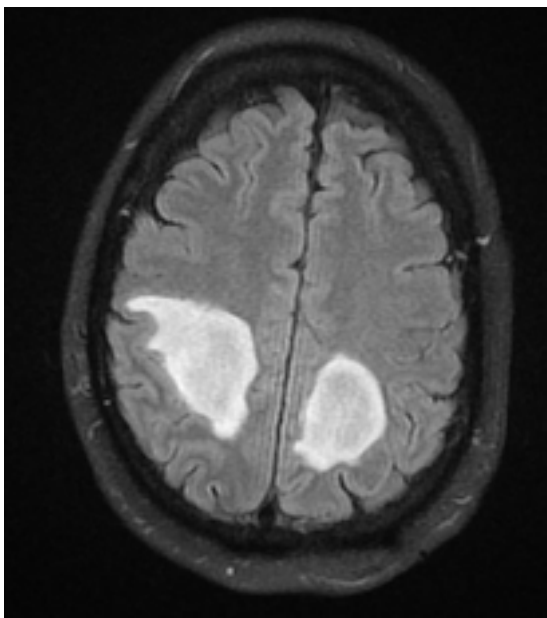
MRI images in T2 Flair sequence taken prior to treatment showing a fairly symmetrical opening enhancing pattern in both parietal lobes
